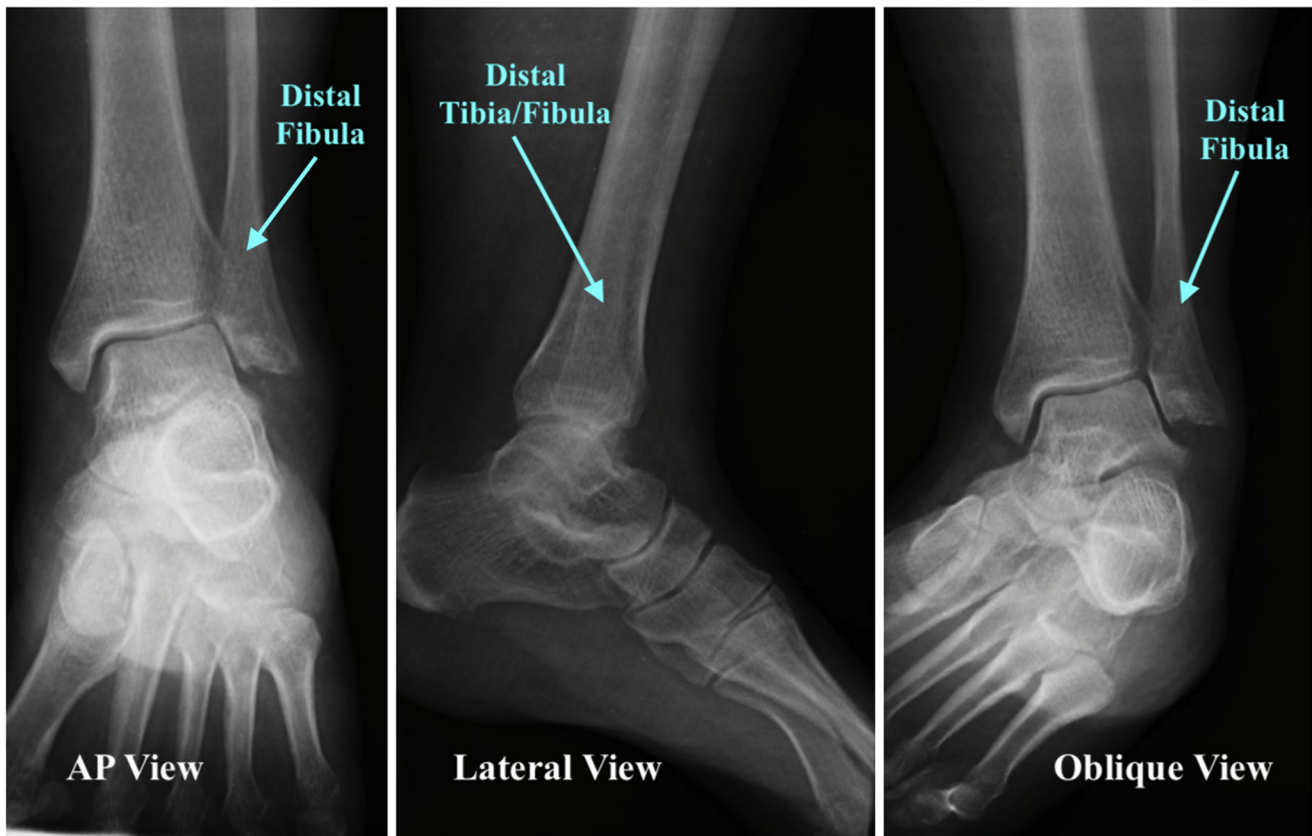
Postoperative radiograph images of the left ankle in the anterior-posterior (AP), lateral, and oblique views. In the AP and oblique view, the nonunion fragment below the distal fibula is absent, which indicates the successful removal of the nonunion. The lateral view indicated no osseous abnormality. The plastic suture anchor inside the distal fibula is not shown under radiographs.
